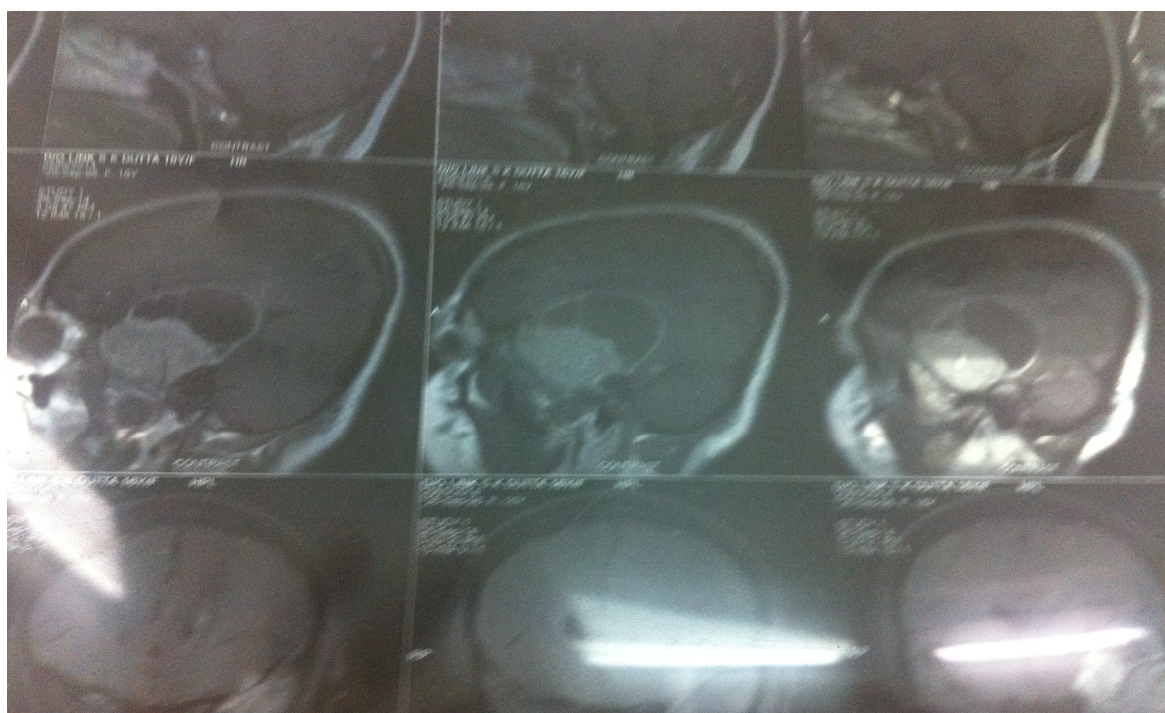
Postcontrast T1 weighted MRI showed intense, homogeneously enhancing osseous tumor in left sphenoid and temporal bone causing destruction of bone.
